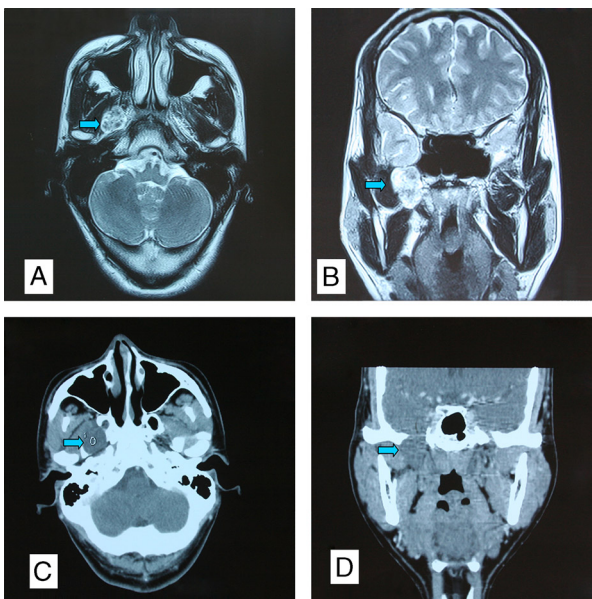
A, Axial T2-weighted MRI shows an uneven tumor in the skull base. B, Coronal T2-weighted MRI shows a tumor below the right foramen ovale. C, Axial CT scan with contrast enhancement shows a nonenhanced mass measuring 2 × 2.5 cm in the skull base. D, Coronal CT scan with contrast enhancement shows that the foramen ovale was dilated by the tumor (arrow shows the mass).
